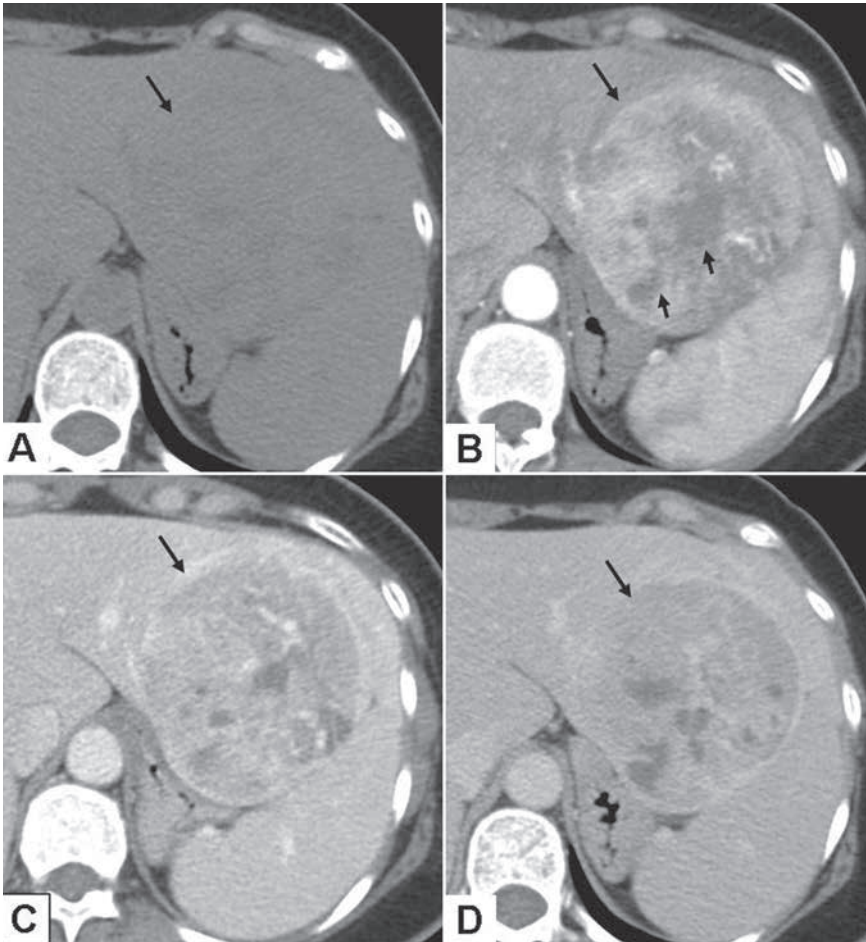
Dynamic three-phase CT scan of the liver. (A) Non-contrast image showing a isodense mass (arrow) in the left lobe of the liver. (B) Arterial phase showing encapsulated mass (arrow) with heterogeneous enhancement and central necrosis (small arrows). (C) Fast washout of the tumor mass (arrow) in the portal venous phase. (D) Delayed phase showing an isodense area of the mass (arrow).
